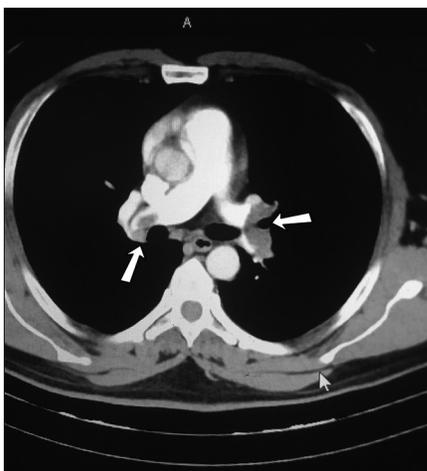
Computed tomography showing bilateral pulmonary embolism
